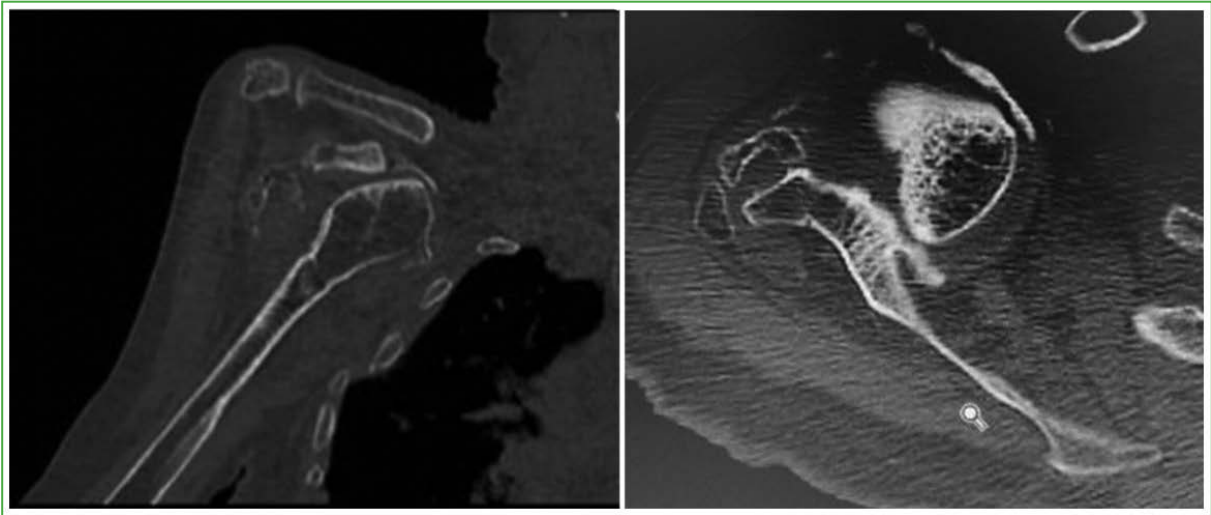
Representative CT images showing the dislocated humeral head impacted anteriorly and an axial view demonstrating anatomic changes in the glenoid with an anterior bone defect >30%.
